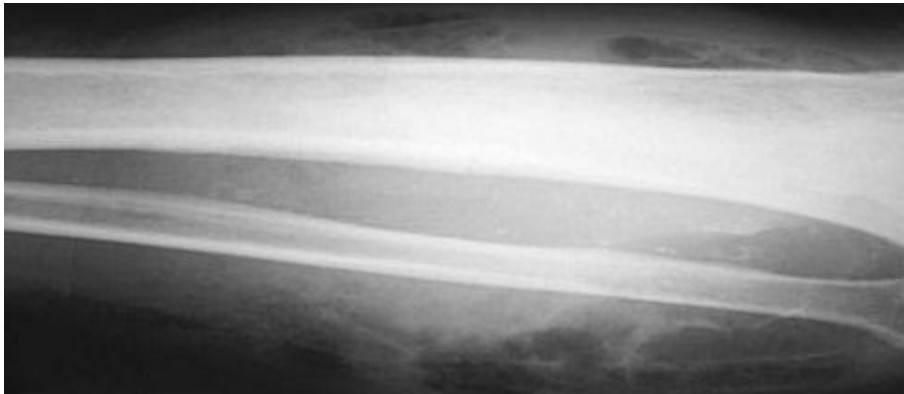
Plain x-ray showing gas in the fascial planes characteristic of gas gangrene
